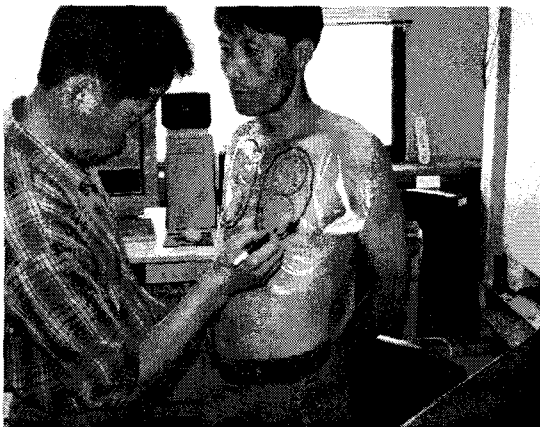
Template and black marker for ultrasound measurements.
